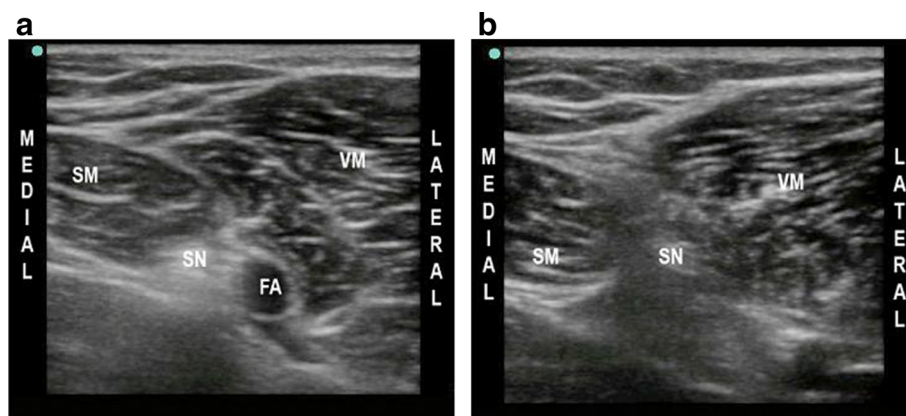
a An ultrasound view of the subsartorial saphenous nerve block. At the mid-femoral level, the probe was placed transversely. *SM* sartorius muscle; *SN* saphenous nerve; *FA* femoral artery; *VM* vastus medialis. b This image was recorded 7 cm proximal to the medial condyle. The probe was placed transversely. *SM* sartorius muscle; *SN* saphenous nerve; *VM* vastus medialis.
